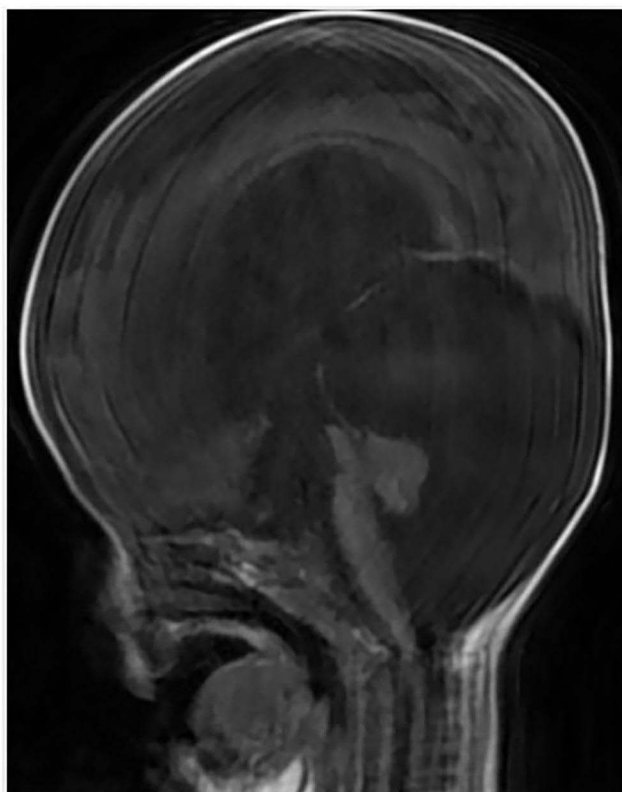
Sagittal T1 MRI showing: upward sloping tentorium cerebelli with Cerebellum and vermian hypoplasia. Enlarged posterior fossa with cystic dilation.
